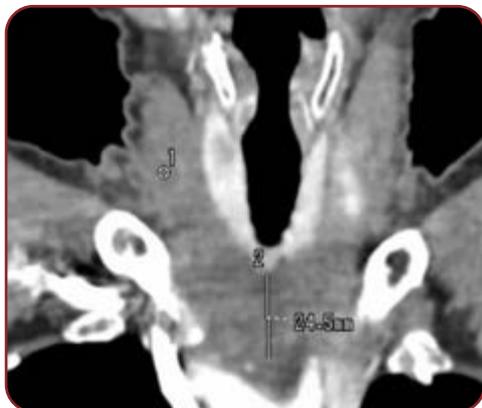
Neck CT scan showing lymphadenopathy
